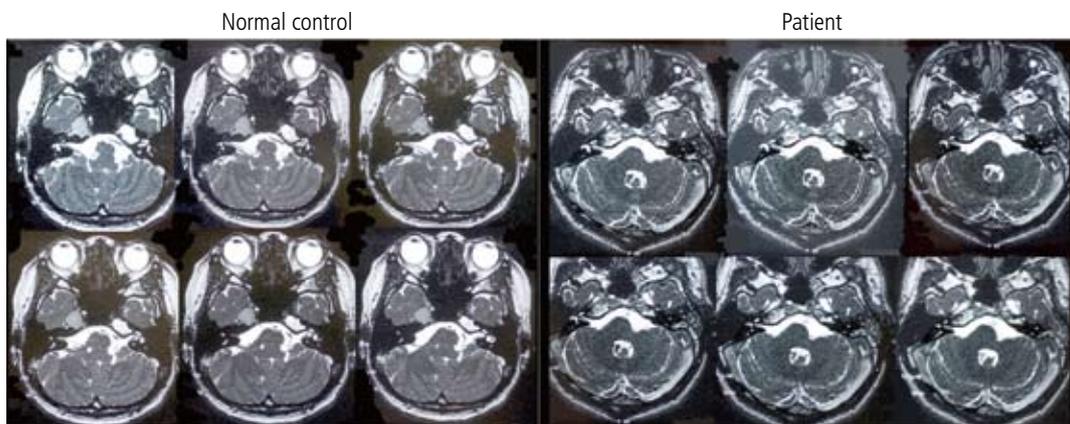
MRI scans of the facial nuclei and nerves
